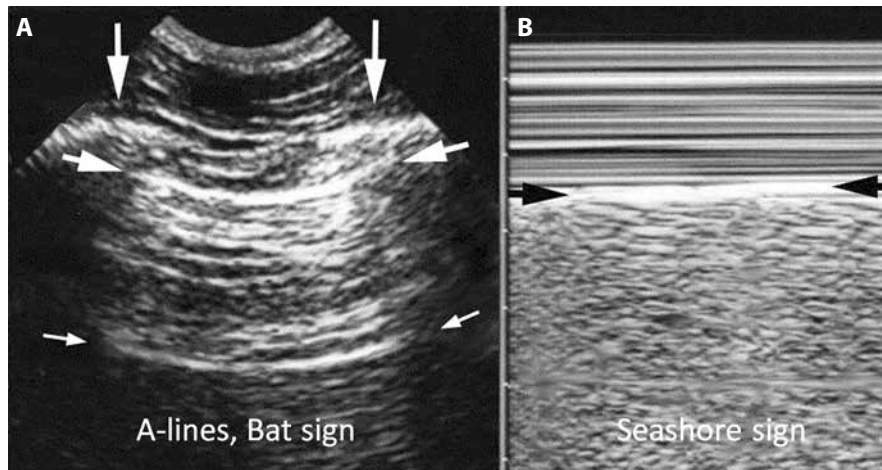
Ultrasound scan of the anterior intercostal space: bat and seashore sign; A — the ribs (vertical arrows) with shadows are visualised. The pleural line (upper, horizontal arrows), is a horizontal hyperechogenic line, half a centimetre below the rib line in adults. The association of ribs and pleural line make a solid landmark called the bat sign. The pleural line indicates the parietal pleura. The horizontal repetition artefact of the pleural line is called the A-line (lower, small horizontal arrows). The A-line indicates that air is the main component visible below the pleural line; B — M-mode reveals the seashore sign, which indicates that the lung moves at the level of the chest wall. The seashore sign therefore indicates that the pleural line also is the visceral pleura. Above the pleural line, the motionless chest wall displays a stratified pattern. Below the pleural line, the dynamics of lung sliding show a sandy pattern. Note that both images are strictly aligned, of importance in critical settings. Both images, i.e. lung sliding plus A-lines, define the A-profile (when found at the anterior chest wall). Adapted from 'Lung ultrasound in the critically ill' [11]
